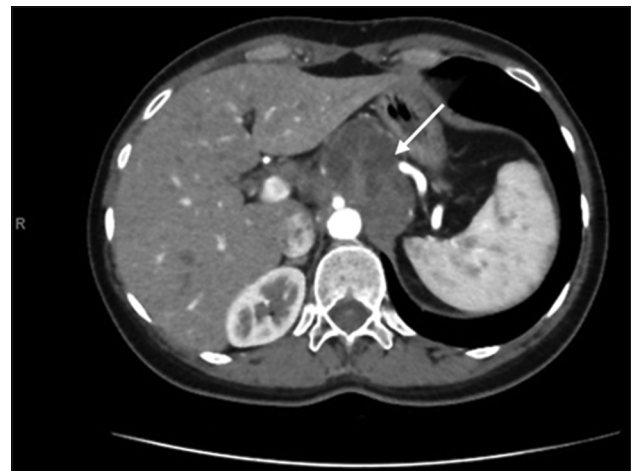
Computed tomography scan showing the abdominal-retroperitoneal disease relapse in an axial plane passing through the celiac axis, encasing celiac axis, superior mesenteric, left gastric, common hepatic arteries, and proximal splenic artery (white arrow).
